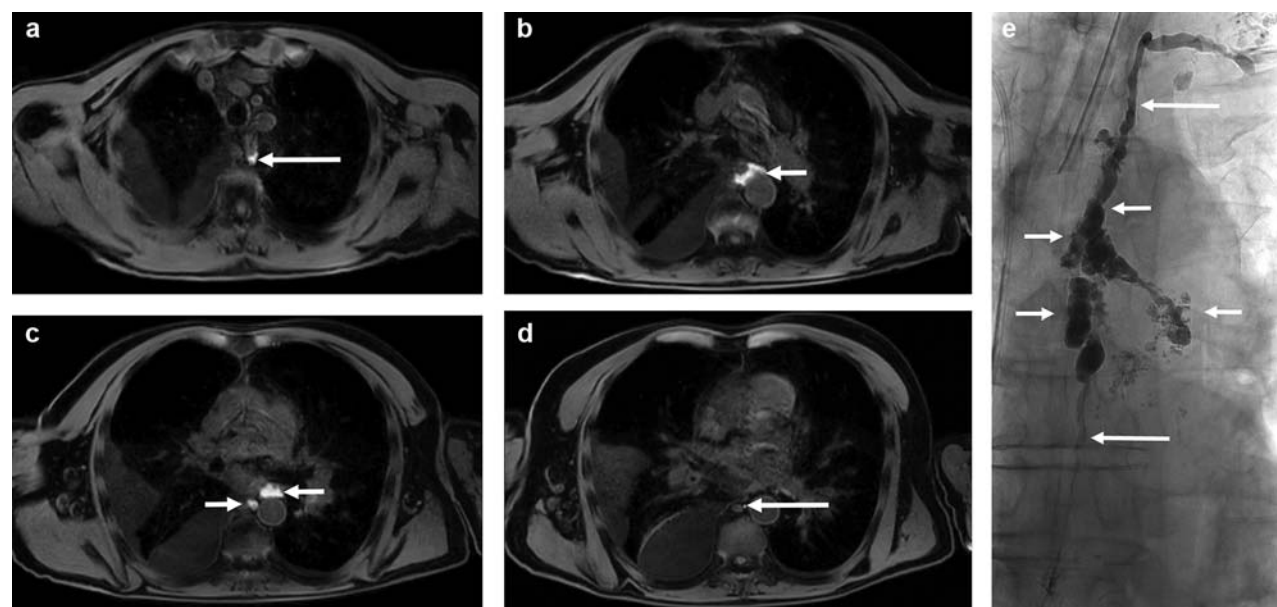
Lymphatic malformation. A 67-year-old man with spontaneous right-sided chylothorax. Axial T1-weighted contrast-enhanced transpedal MR lymphangiography (a–d) and corresponding digital X-ray lymphangiogram (e). MRL and X-ray lymphangiography demonstrates cystic lymphangiectasia in the posterior mediastinum (short arrows) as well as a normal caliber thoracic duct (long arrows) above and below the pathologically dilated lymphatics. Chylothorax resolved completely after embolization.
